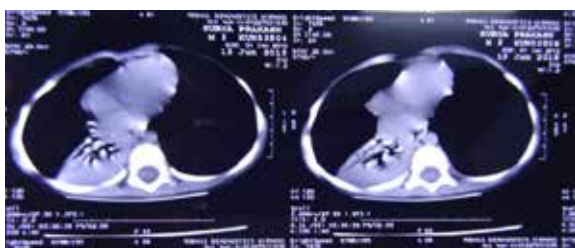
CT Scan of thorax pneumonic consolidation right lower lobe
